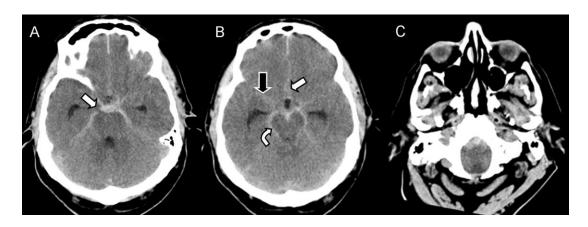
The definition of perimesencephalic haemorrhage: Hemorrhage centered anterior to the midbrain and/or pons within the pre-pontine and interpeduncular cisterns (A, white arrow), with possible extension to the quadrigeminal or ambient cisterns (B, curved arrow). No deep extension into the anterior interhemispheric fissure (B, white arrow). Possible extension into the basal parts of the sylvian fissures with no extension into the lateral sylvian fissures (B, black arrow). 4. Possible extension to the cisterna magna but not centered on the cisterna magna (C). The latter feature was associated with a possible vertebral dissection in this study (see figure A2) and removal of this criterion resulted in a NPV of 100% for CTA, suggesting that cisterna magna haemorrhage should not be present if DSA is no be avoided.
